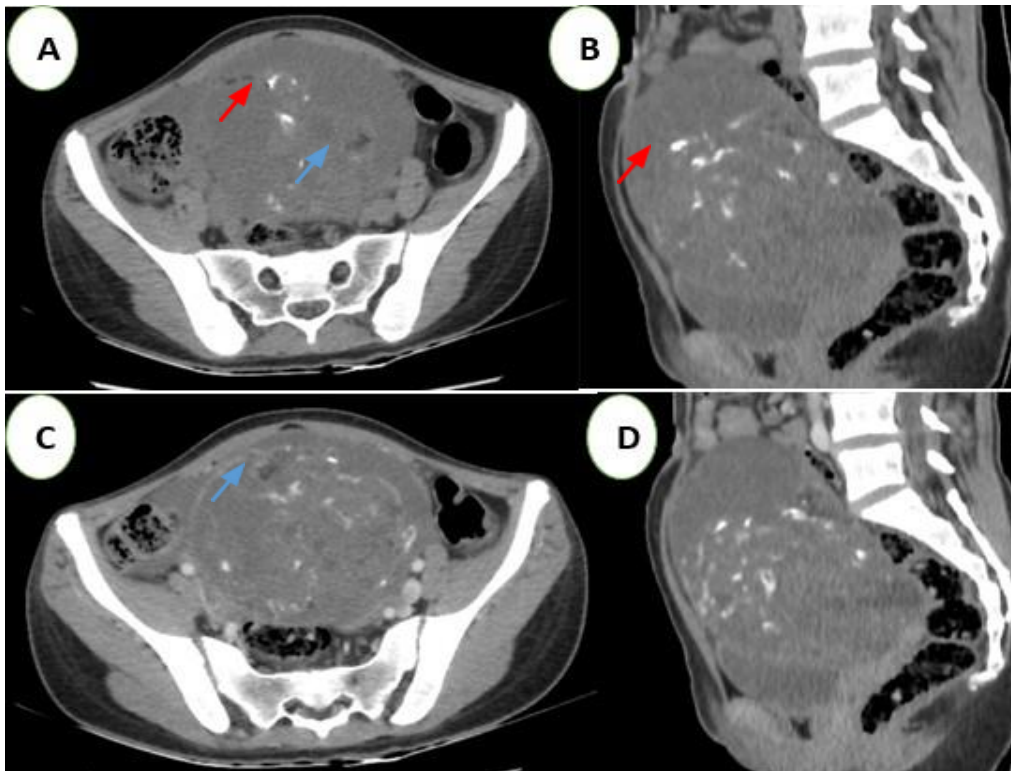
Abdominopelvic CT Scan without (A and B) and with contrast injection (C and D), in axial (A and C) and sagittal (B and D) slices
